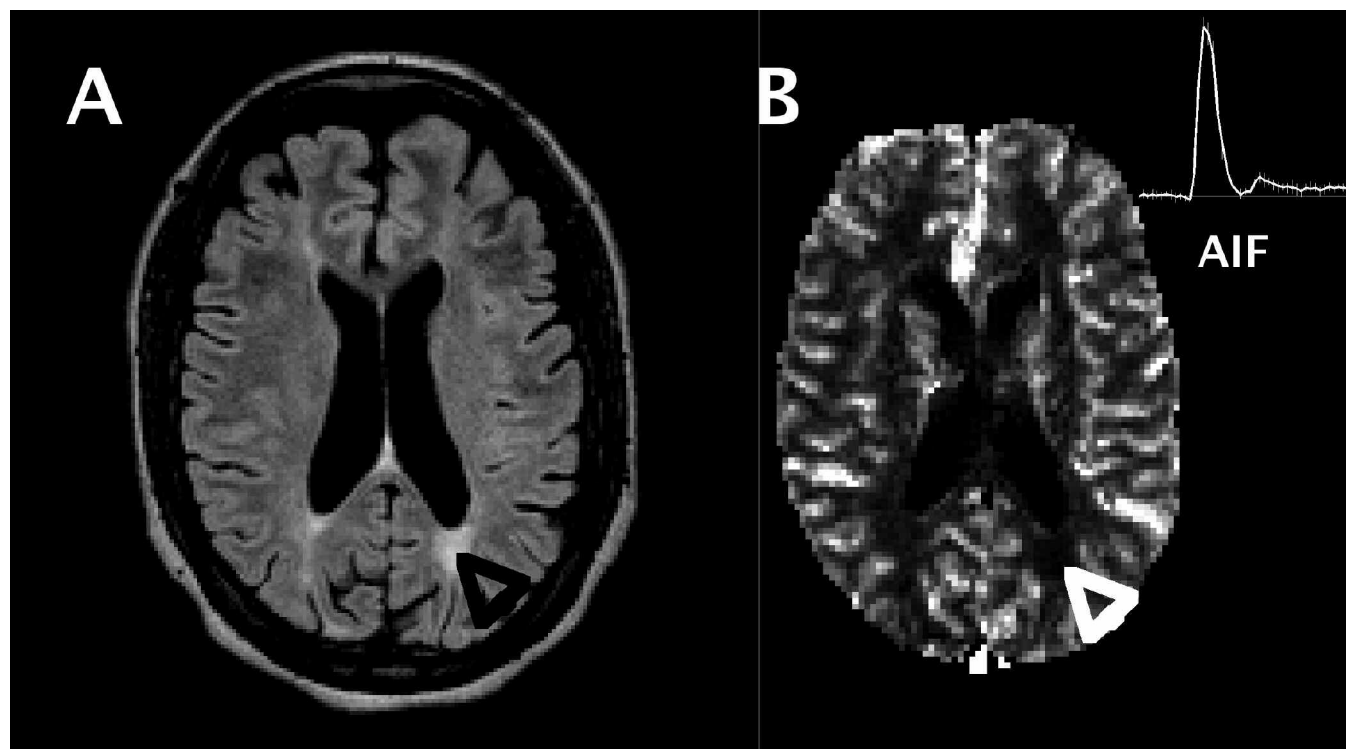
A. FLAIR image from one patient with SLE, with a white matter lesion indicated by black arrow (lower right quadrant of image). B. Cerebral blood flow (CBF) map from same subject showing reduced CBF in region of lesion (white arrow) and arterial input function (AIF) time course (upper right corner).
